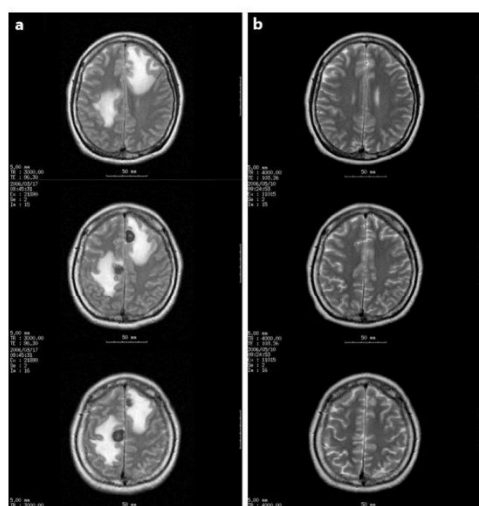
MRI in March 2006 showed multiple metastatic tumors approximately 18 mm in diameter as well as surrounding brain edema in the bilateral frontal lobes (a). After GKS, the tumors had reduced in size by May 2006 (b).
